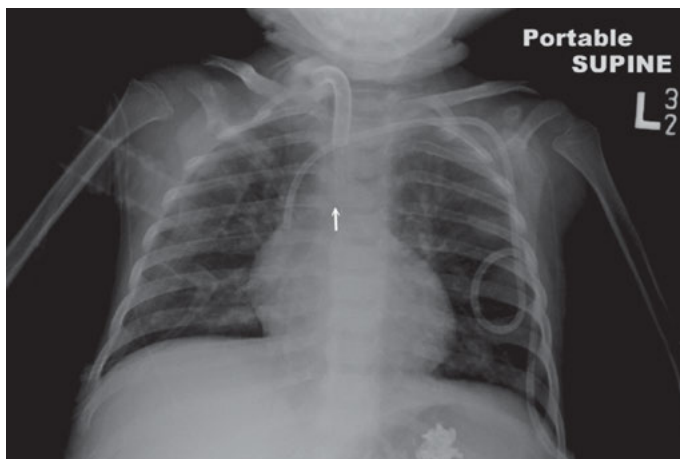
A postoperative plain chest radiograph is ordered either on the operating table or in the recovery room to verify good placement of the tracheostomy. Ideally, the tip of the cannula should be located in the mid-trachea, half way between the insertion site and the carina (white arrow).
